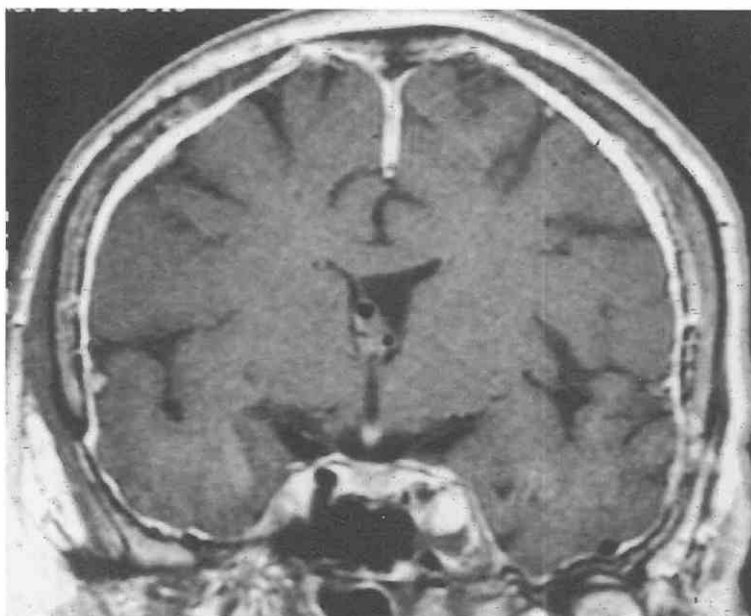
Postoperative meningeal enhancement. Coronal T1-weighted image shows diffuse, linear enhancement in a patient who had undergone previous craniotomy for meningioma.
